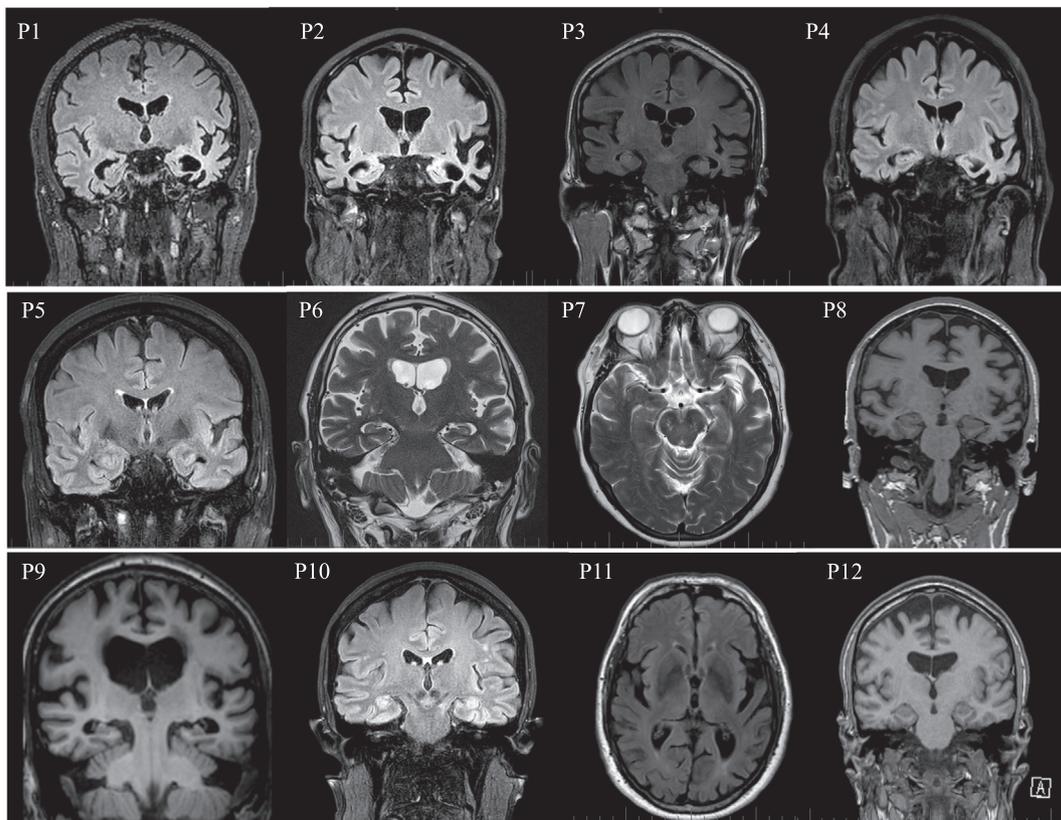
MRI scans of participants diagnosed with svPPA (P1, P2, P3 and P4), lvPPA (P5, P6, P7 and P8), and AD (P9, P10, P11 and P12).
